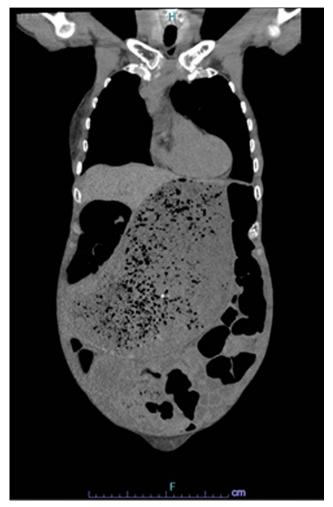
Computed tomography of abdomen showing distention of the stomach.
